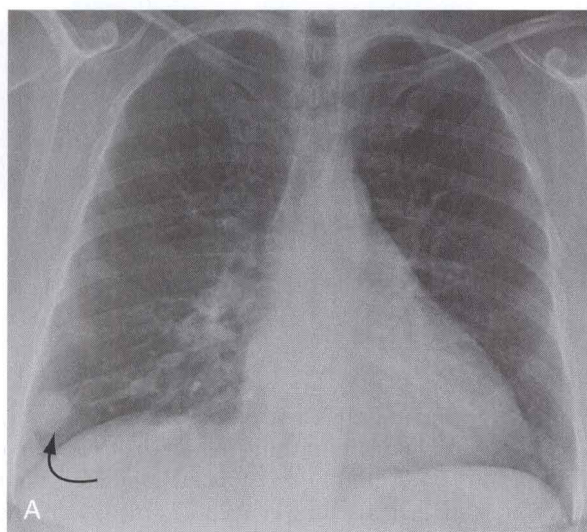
A, Incidental nodule (arrow) was discovered on a routine chest radiograph in a 47-year-old woman. B, Non-contrast-enhanced chest CT scan demonstrates laminated calcifications typical for previous infection with histoplasmosis (arrow). The nodule remained stable at 5-year follow-up evaluation by chest CT (not shown).
